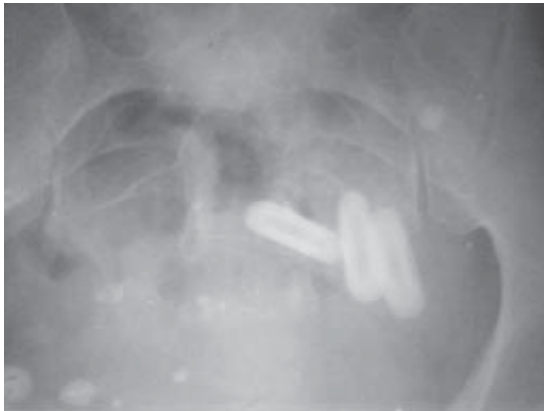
X-ray showing Radio opaque densities in Pelvis
